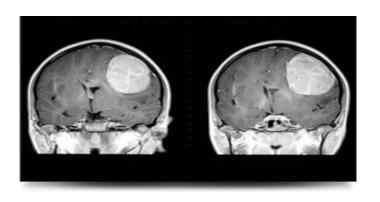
MRI showing brain Tumor
